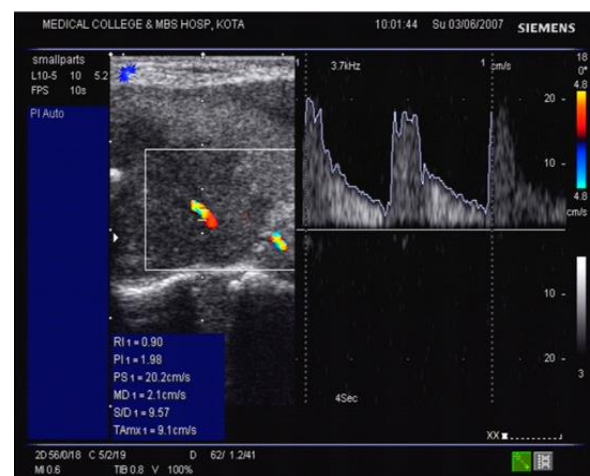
Pulse Doppler image shows RI 0.90 and PSV 20.2 cm/sec.
